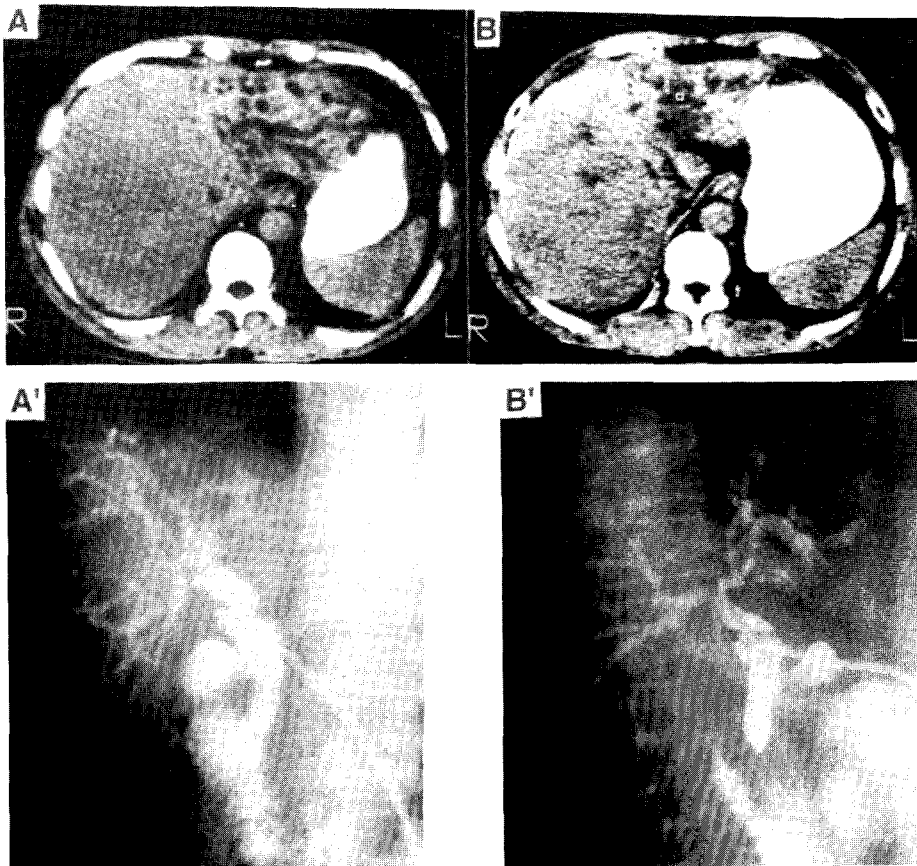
Pretreatment CT scan (A) and T-tube cholangiogram (A') shows dilated intrahepatic biliary trees in the left lobe of the liver and non-visualization of the left extra-hepatic duct. After external irradiation of 4500 cGy combined with hyperthermia the dilated intrahepatic biliary trees are relieved (B) and the left extrahepatic duct are recanalized (B').
